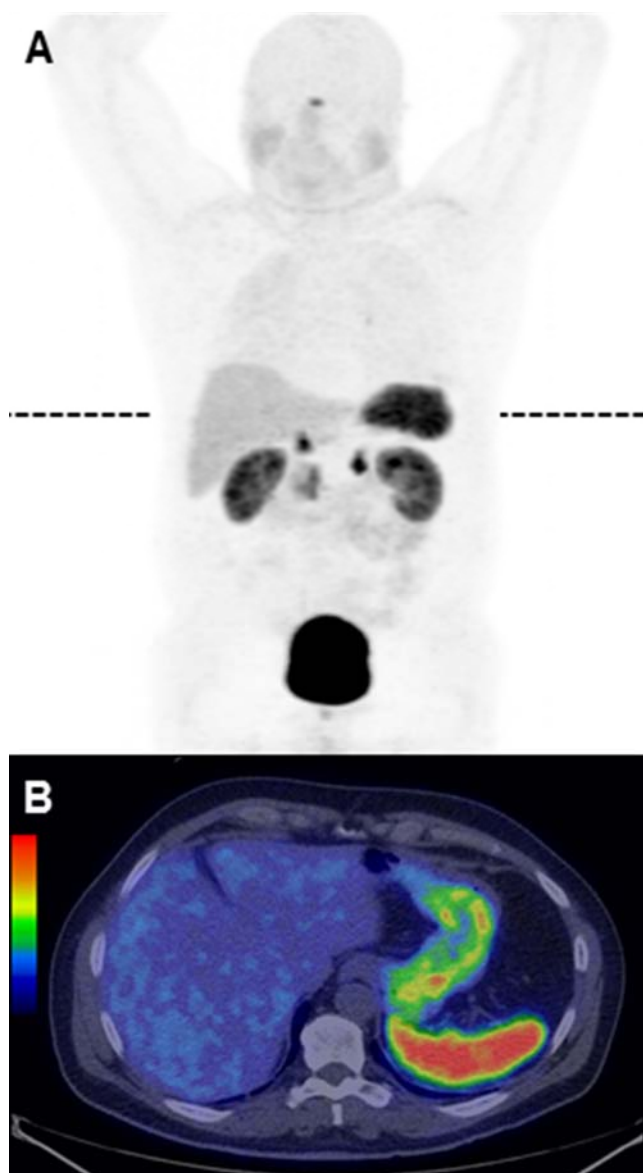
Biodistribution of 175 MBq ^{68}Ga -OPS202 (15 μg) 1 h post-injection in patient 11 with NET of the ileum. Currently the patient is in complete remission. (A) Shows the whole-body PET scan and dotted lines show the level of the transaxial PET/CT slice (B). There is low background activity in the salivary glands, liver and intestine.
